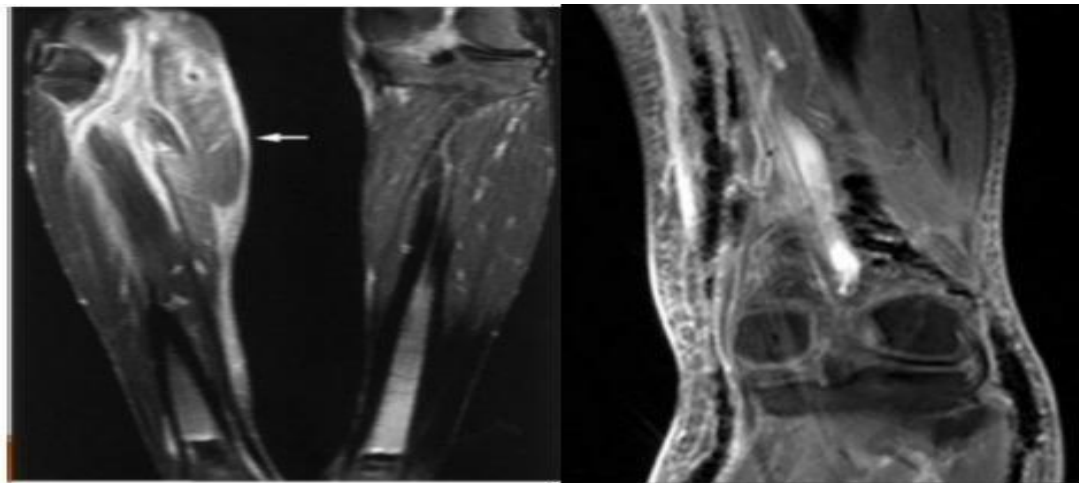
MRI shows Necrotising fasciitis of right lower limb shows fascial thickening and hyper intensity, starting in the superficial fascia involving deep muscular fascia in multiple compartments, sub-fascial and inter-fascial fluid collection, low signal foci of gas and subcutaneous edema.
